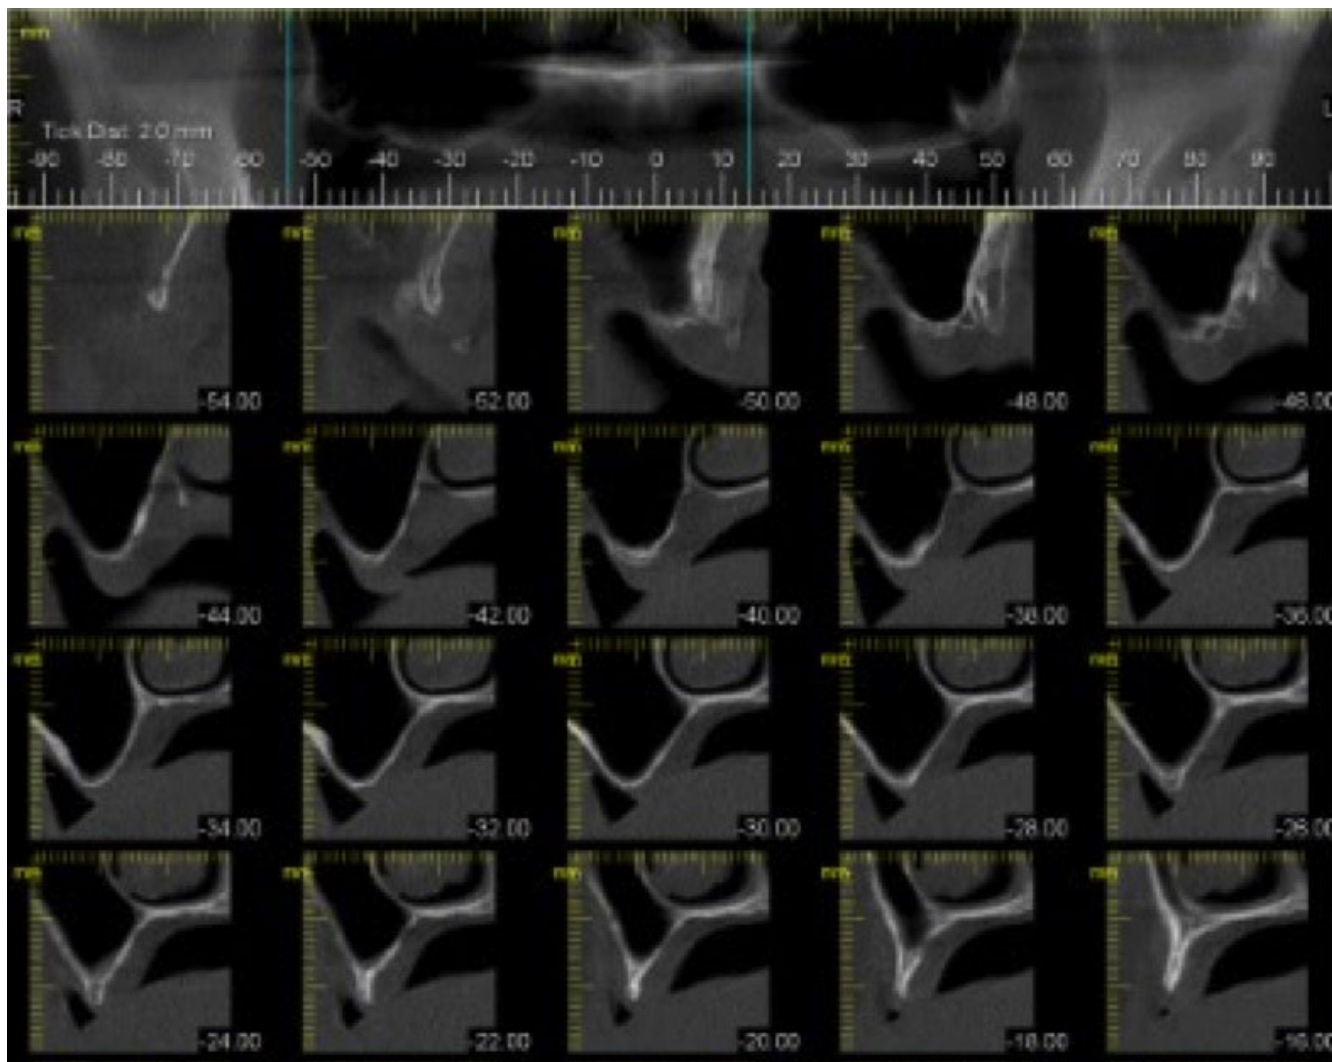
Cone beam CT of atrophic edentulous maxilla.
